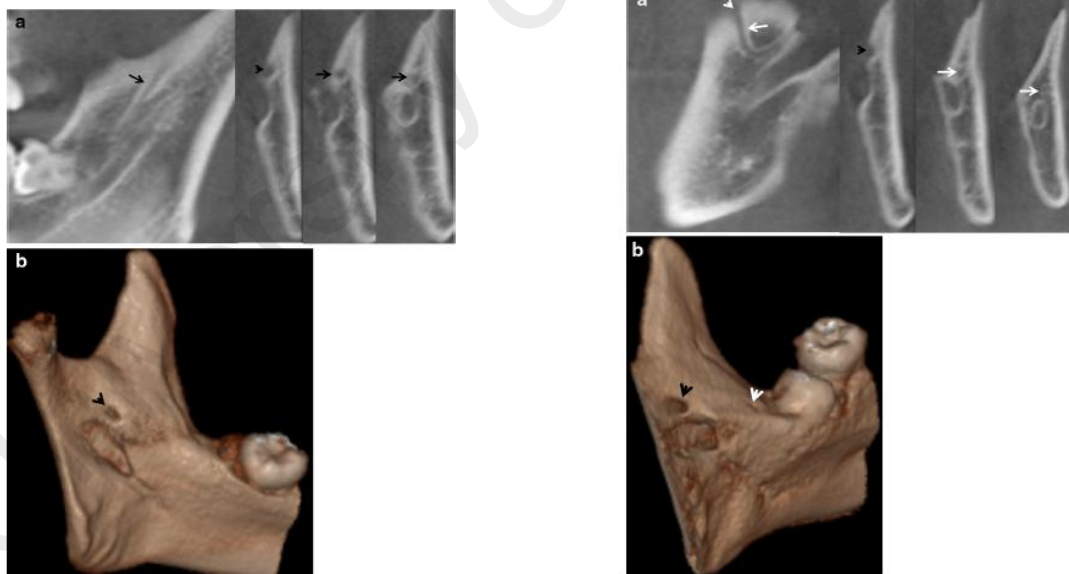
CBCT images of forward and retromolar canal type from DMnF (Choi & Han, 2014)
